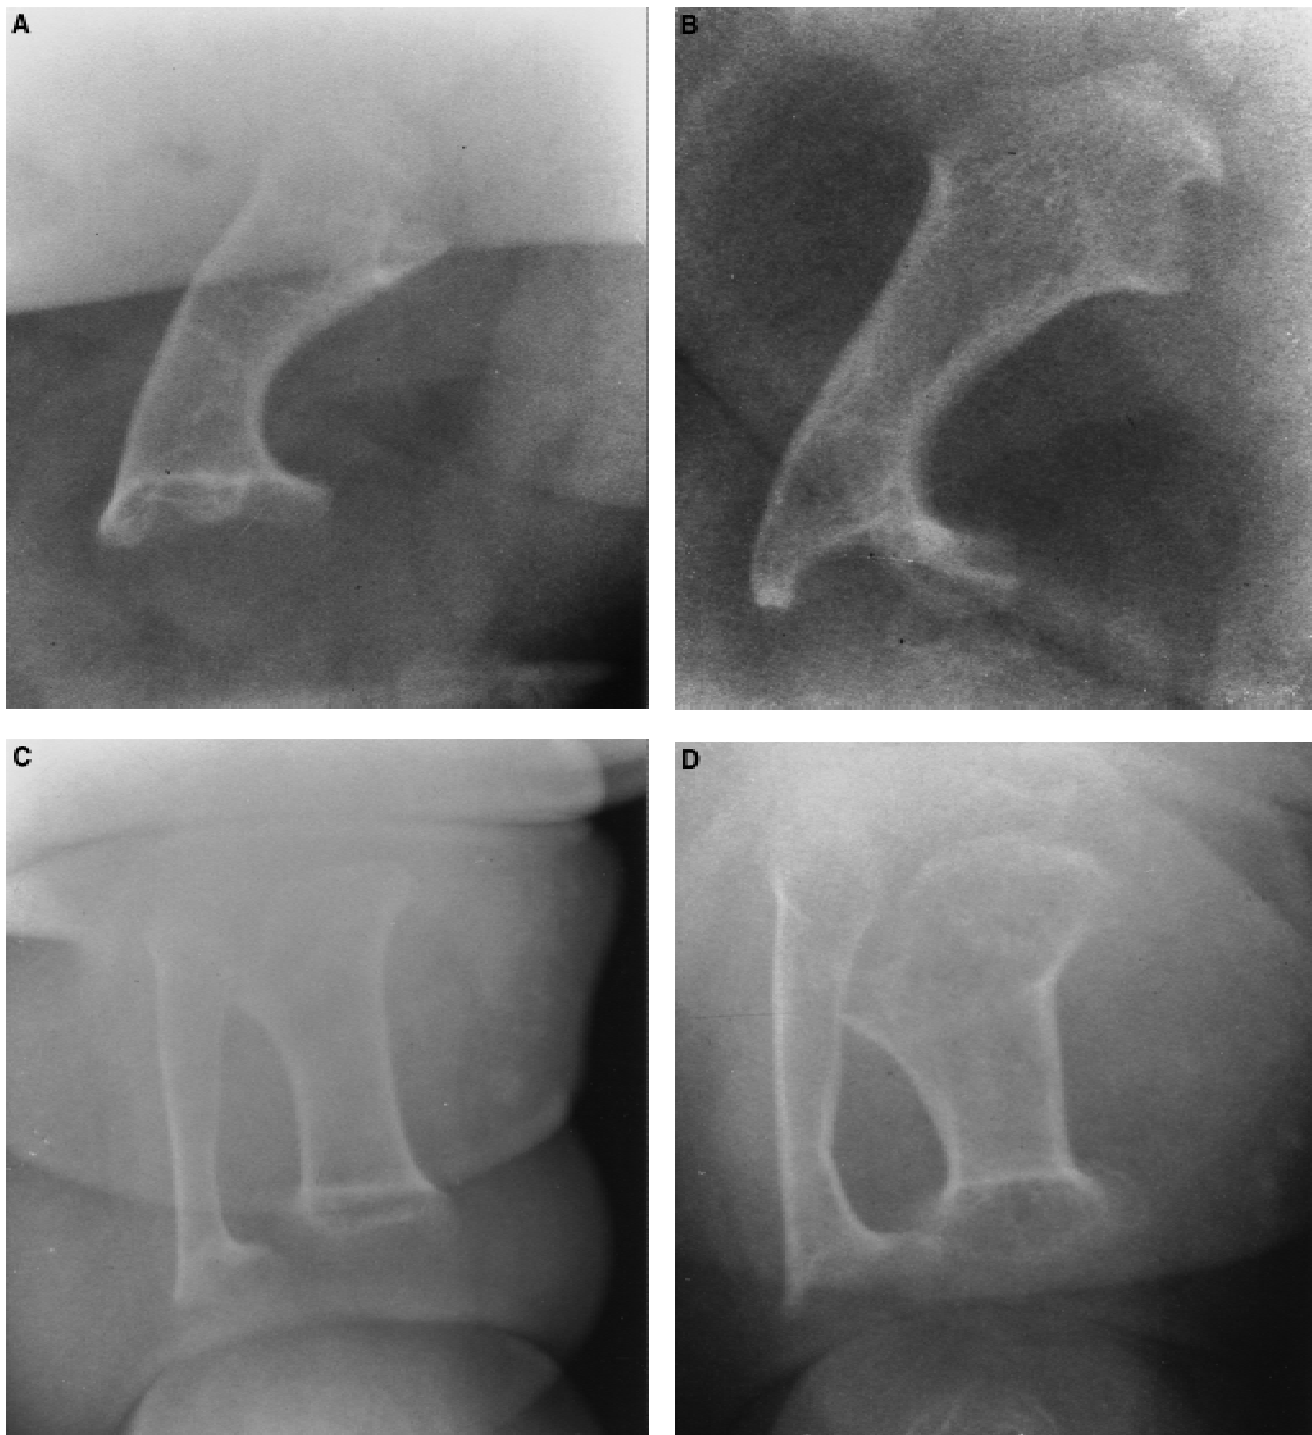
Femur radiographs at 2.3 years (A) and 7.2 years (B) and tibia/fibula radiographs at 2.3 years (C) and 7.2 years (D).
